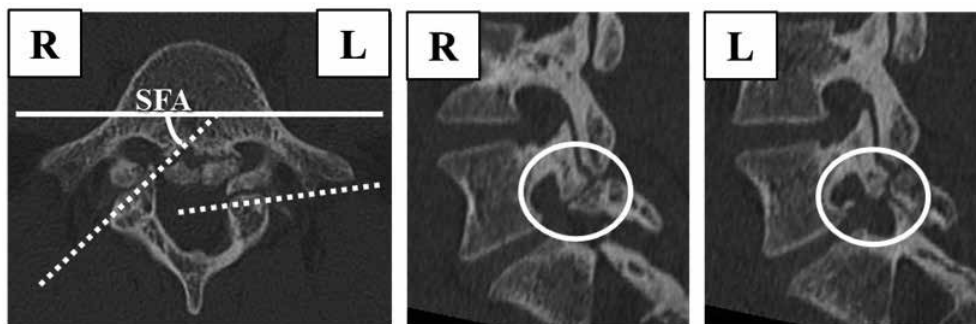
Computed tomography images show a difference in SFA between the left and right sides. SFA ; spondylolysis fracture angle, R ; Right, L ; Left
